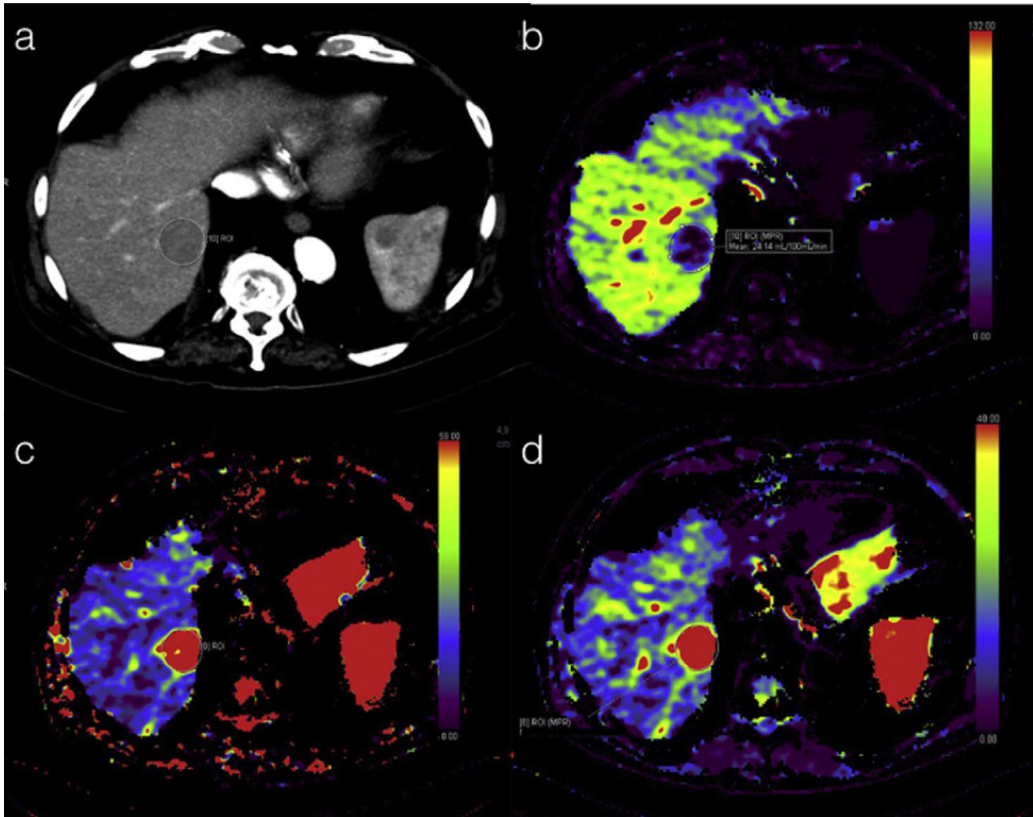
Axial CT images from liver perfusion CT (a). The region of interest (HCC treated by DEB-TACE) is marked by a circle on the PLP map (b). The software marks the same region on the ALP (c) and the HPI (d) color maps.
